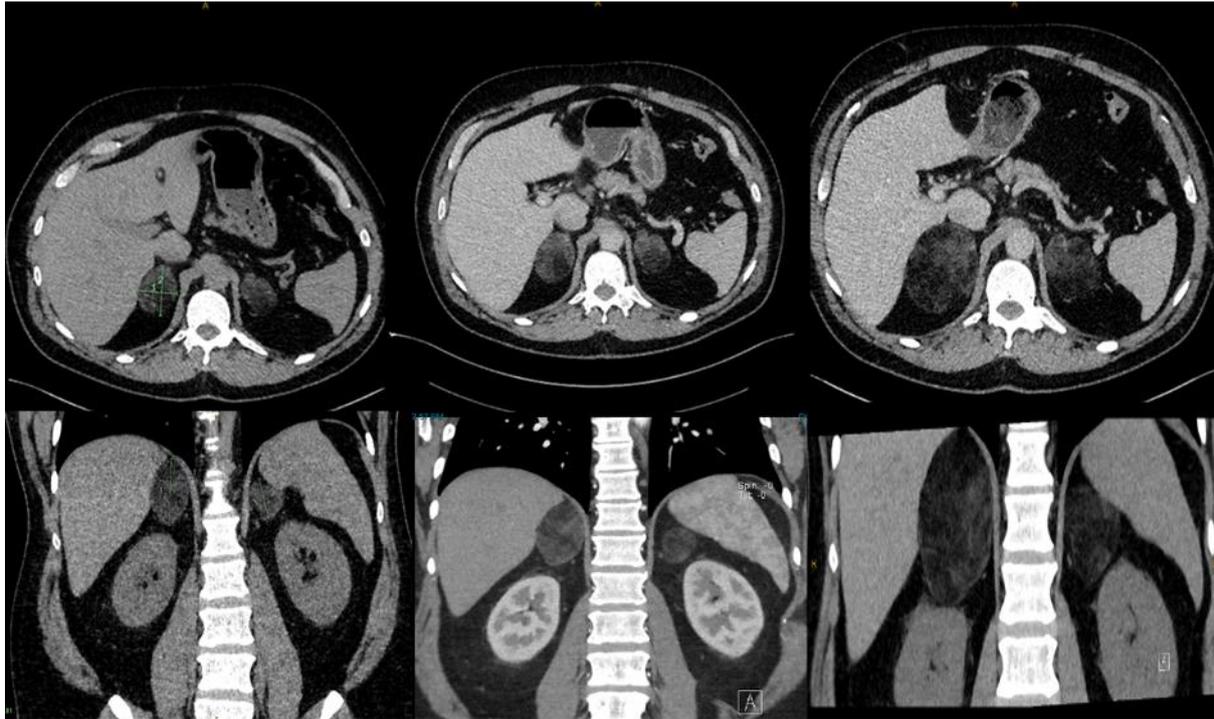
CT (Right to left) right adrenals: 52 x 32 x 47 mm (2017), 54 x 31 x 59 mm (2018), 73 x 65 x 82mm (2021).
